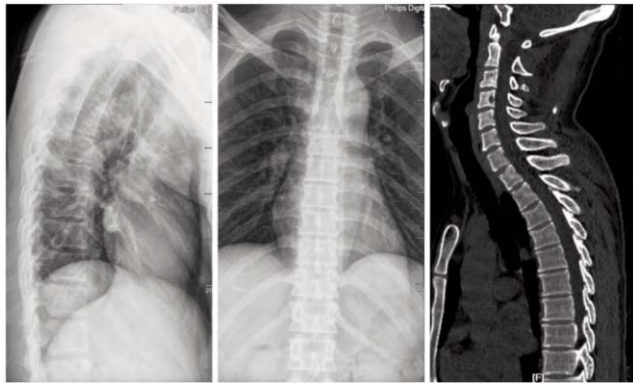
No fracture or dislocation was found on X-ray and CT of the thoracic spine.
